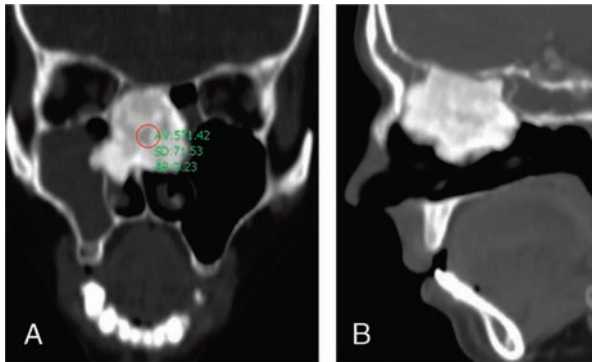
Coronal (A) and sagittal (B) computed tomographic images. The mass lesion in the upper nasal cavity and density consistent with a giant osteoma. The mass lesion shows extension into the right maxillary sinus.
